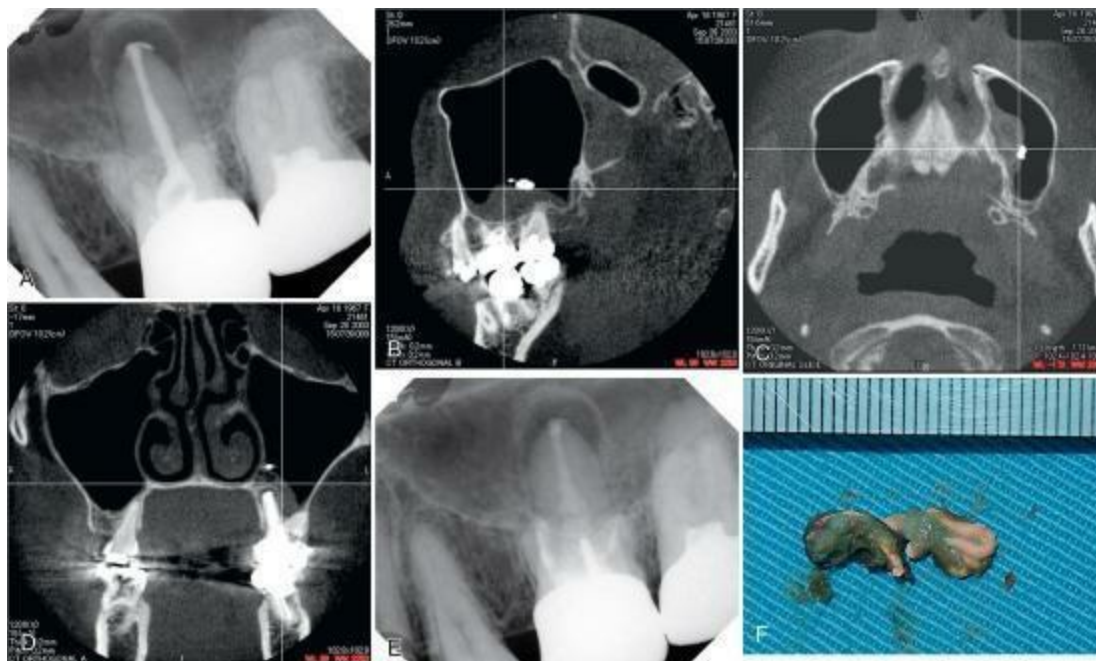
Maxillary sinus aspergillosis. A, Preoperative radiograph showing a lesion associated with the palatal root, from which the extrusion of the root filling materials occurred in the maxillary sinus. B, Cone-beam computed tomography (CBCT) image in sagittal view showing the relation between mucositis on the maxillary sinus floor and the gutta-percha filling materials. C, CBCT image in axial view showing the relation between mucositis on the mesial wall of the maxillary sinus and the extruded root filling materials. D, CBCT image in coronal view showing the relation between the palatal root and the extruded root filling materials. E, Postoperative radiograph of orthograde root canal retreatment on the maxillary left first molar showing the mesiobuccal, distobuccal, and palatal root canals were adequately filled without overextension of the filling materials. F, Aspergillus was found on the filling materials retrieved from the maxillary sinus.
